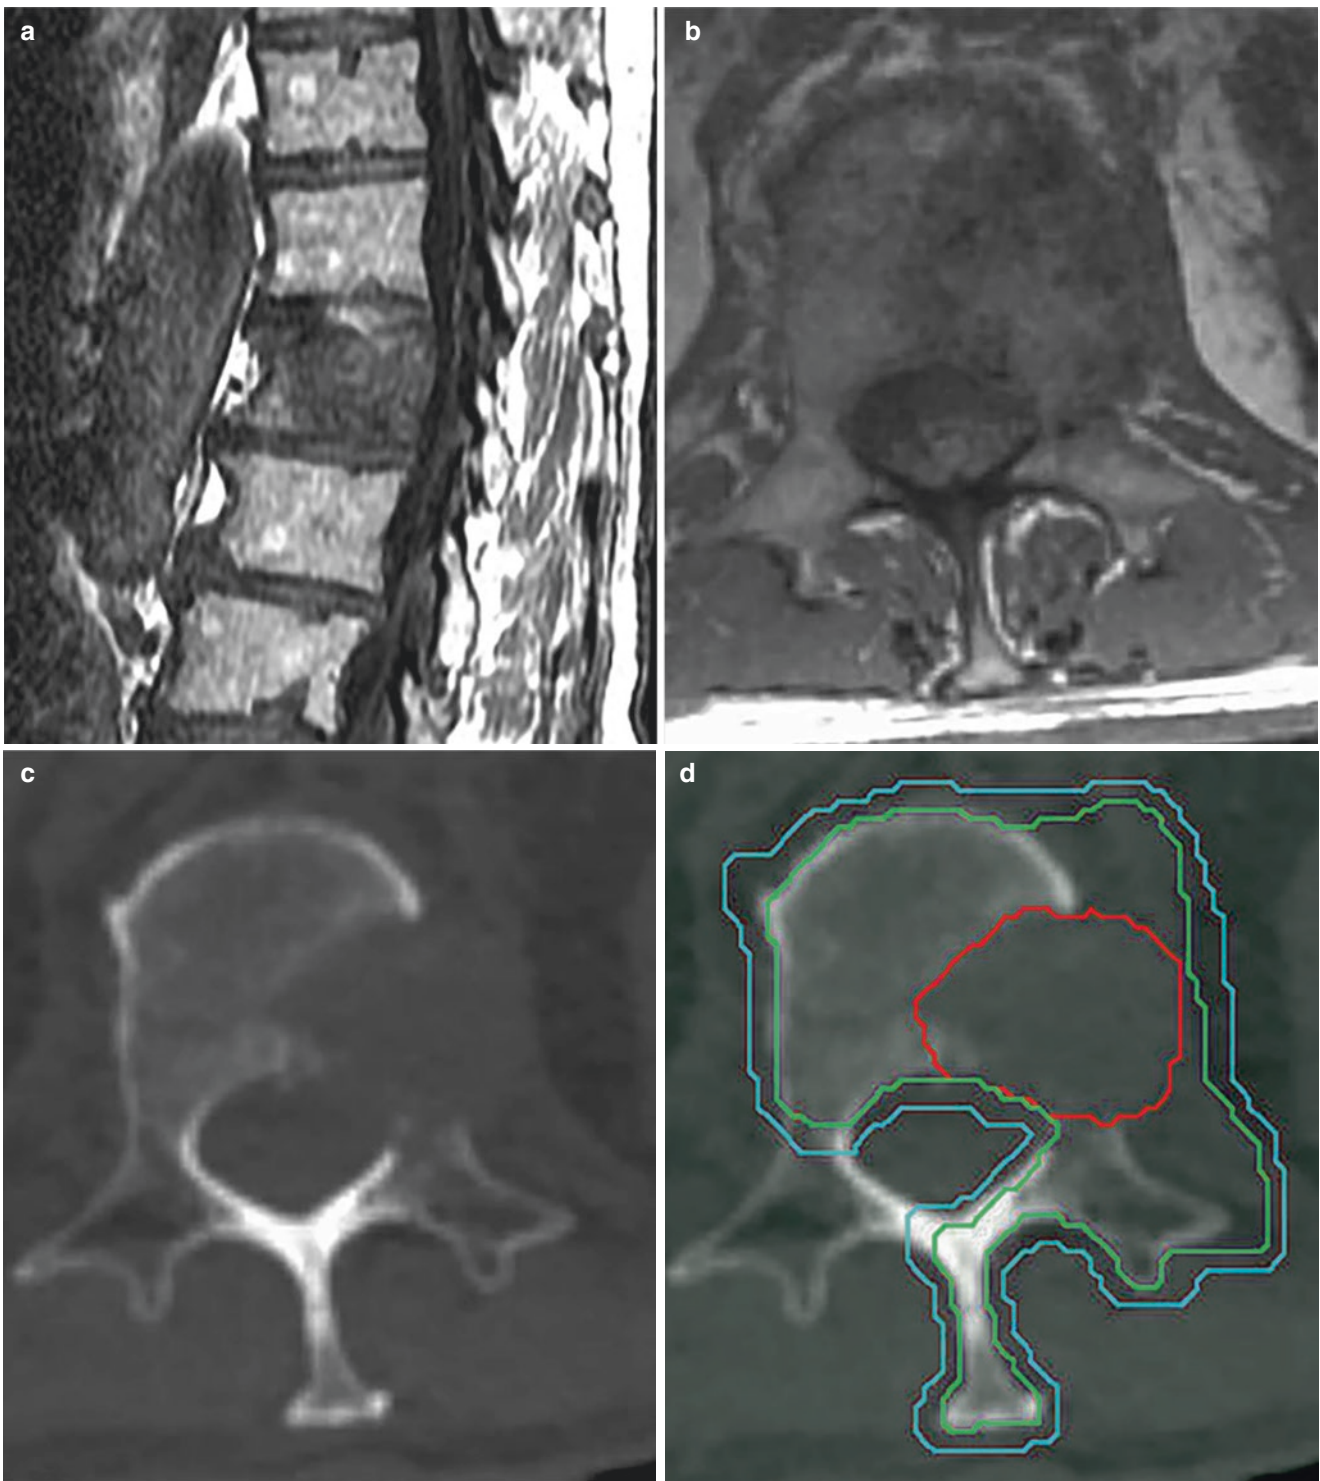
(a–d) Case of a 77-year-old gentleman with renal cell carcinoma presenting with mechanical pain of his lower back. MR imaging revealed a 2.6 cm mass involving the left side of his vertebral body and extending to his pedicle. Sagittal (a) and axial (b) T1 MRI images and CT (c) of his L1 spinal segment are displayed above. He was treated with 24 Gy in 2 fractions. The GTV includes all gross disease (d), displayed in red. CTV includes the GTV, the spinal segments involved
